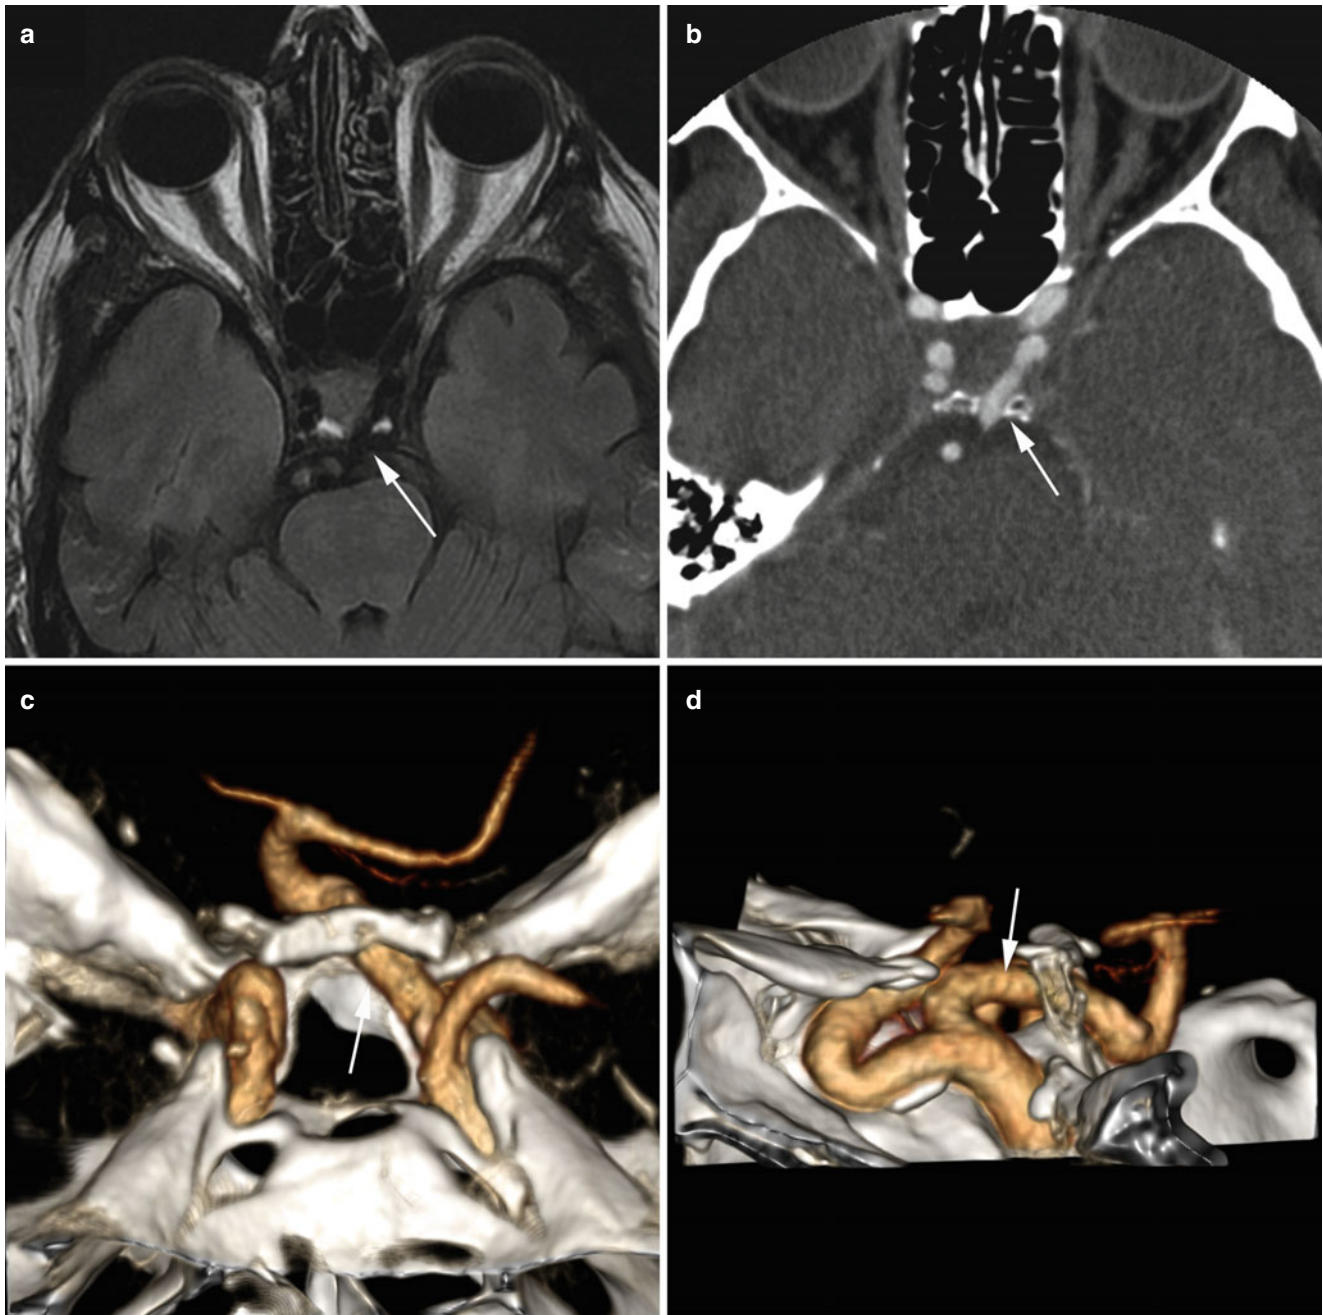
Persistent trigeminal artery (PTA) extending through the sella turcica and pituitary gland. (a) Axial noncontrast MRI showing a flow void through the dorsum sellae (*arrow*) arising from the left ICA. (b) Axial CT angiogram showing the PTA arising from the left ICA (*arrow*) and communicating with the basilar artery system after passing
